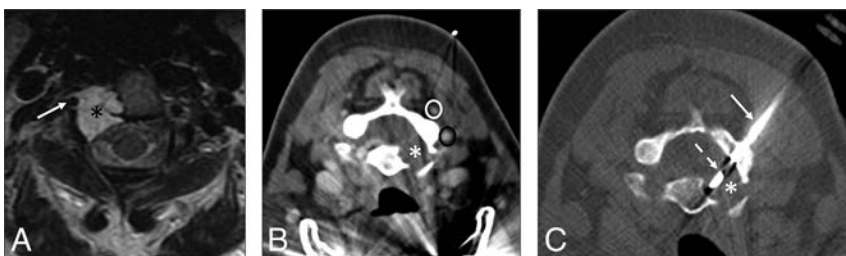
A 55-year-old woman with right neck and arm pain. A, Axial T2-weighted MR image with a large right C2 vertebral mass (black asterisk) surrounding the vertebral artery (white arrow). B, Intraprocedural CT angiogram soft-tissue-windowed image with the patient prone shows the mass (white asterisk) and adjacent vascular structures (deep cervical vein, white oval; vertebral artery, black oval). C, Intraprocedural CT bone-windowed image with the patient prone demonstrates the bone-access needle (white arrow) in the posterolateral right lamina of C2 and a soft-tissue biopsy needle (dashed white arrow) placed coaxially into the mass (white asterisk), using a posterolateral approach. The surgical pathology result was chordoma.
